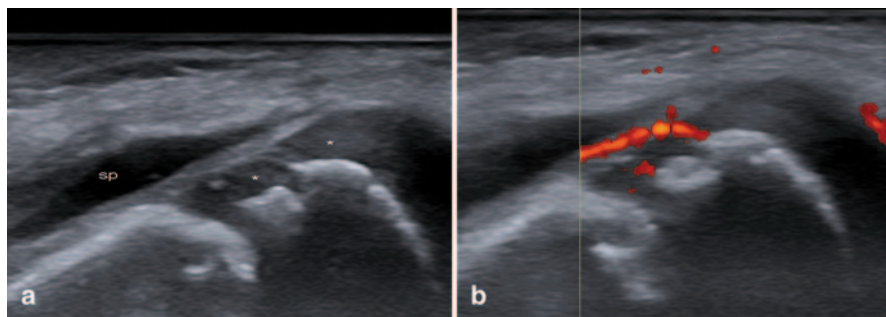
Juvenile idiopathic arthritis in the knee joint. a Longitudinal B-mode US image shows the presence of suprapatellar bursitis (*sp*), erosion and decreased homogeneous hypoechogenicity of the femoral epiphyseal cartilage (*stars*). b Longitudinal Power Doppler US image pathologic vascularization involving the synovial tissue and epiphyseal cartilage close to the erosion. *e* secondary ossification center in epiphysis
